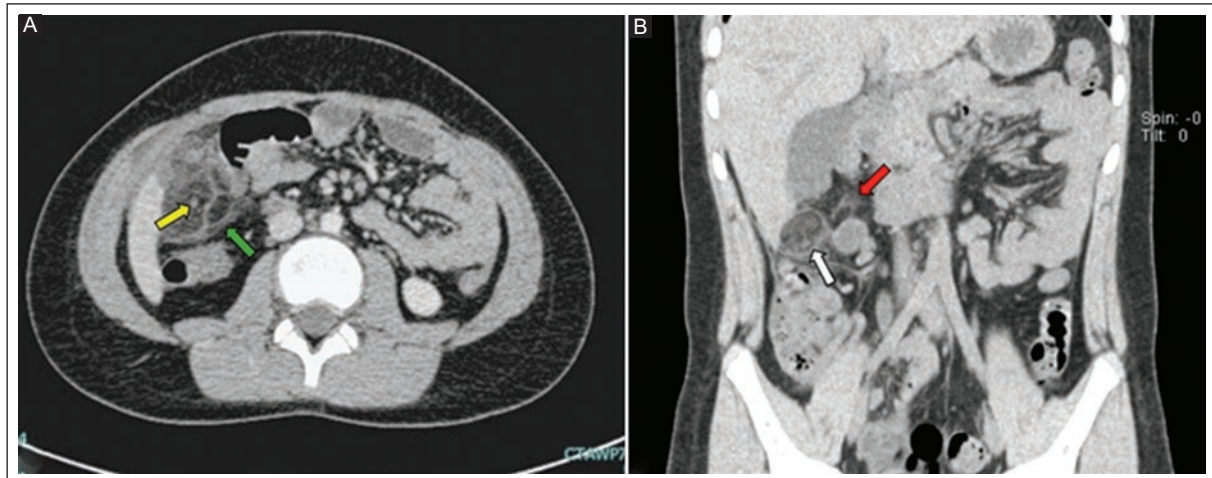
Axial abdominal contrast-enhanced CT. A: showing a hyperdense central dot (yellow arrow) associated with inflammation of the epiploic appendix (green arrow). B: coronal plane view showing fat tissue obliteration (red arrow) with a peripheral hyperdense area, the “hyperattenuating ring” sign (white arrow).
